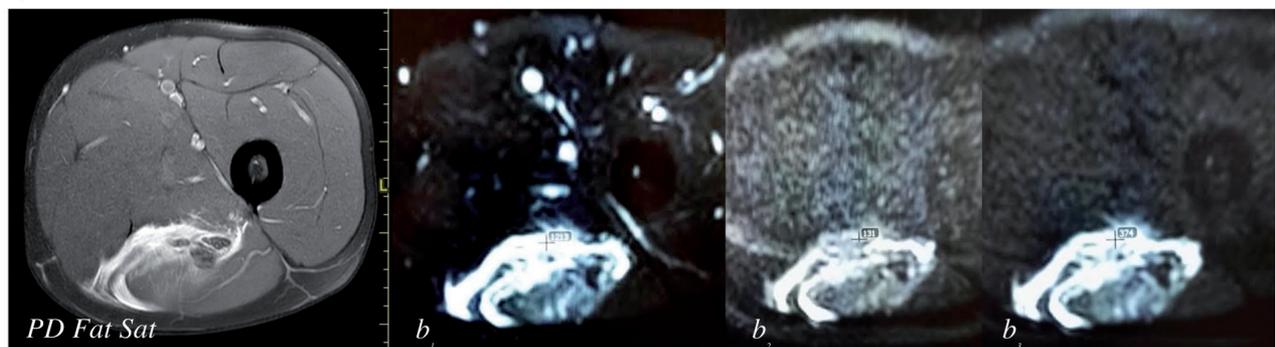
ROI placement on DWI sequences (b_1 , b_2 , b_3) in 3a type (1) and 3b type (2)
